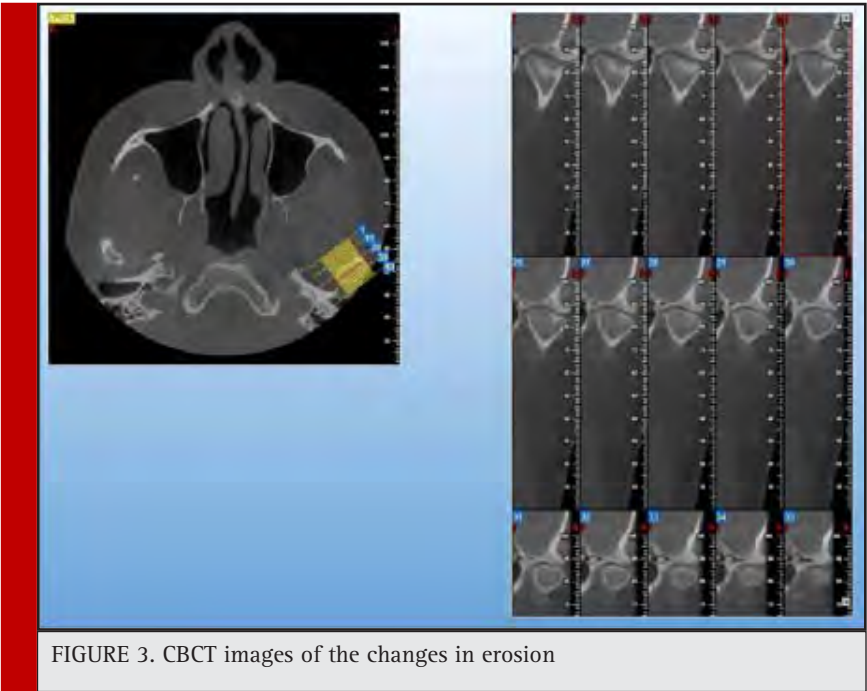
CBCT images of the changes in erosion
